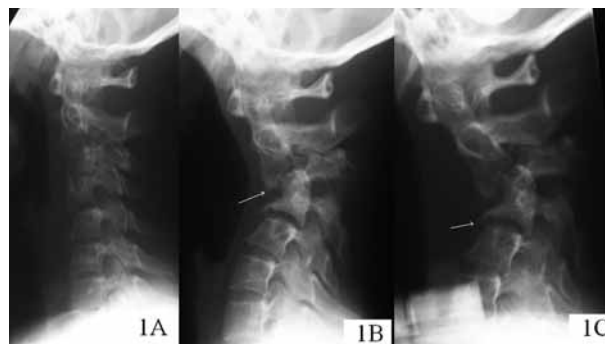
Plain lateral radiographs of the cervical spine showing sequential progression of the kyphotic deformity ; a) plain lateral radiograph at initial presentation, note obliteration of the cervical lordosis with Grade I spondylolisthesis at C2/3 and C4/5. Also, note the reduced C3/4 disc space. b) plain lateral radiographs of the cervical spine, 7 weeks later, showing a kyphotic deformity at C2/3 and fusion of C3/4 vertebral bodies. White arrowhead indicates the phenomenon of anterior point loading of C2 and preferential destruction of the anterior cortex of C3/4. c) radiographs at the end of 10 weeks with gross destruction of C3/4 bodies and toppling of C2 on the rounded superior endplate of C3. The arrowhead indicates fluffy new bone formation.
